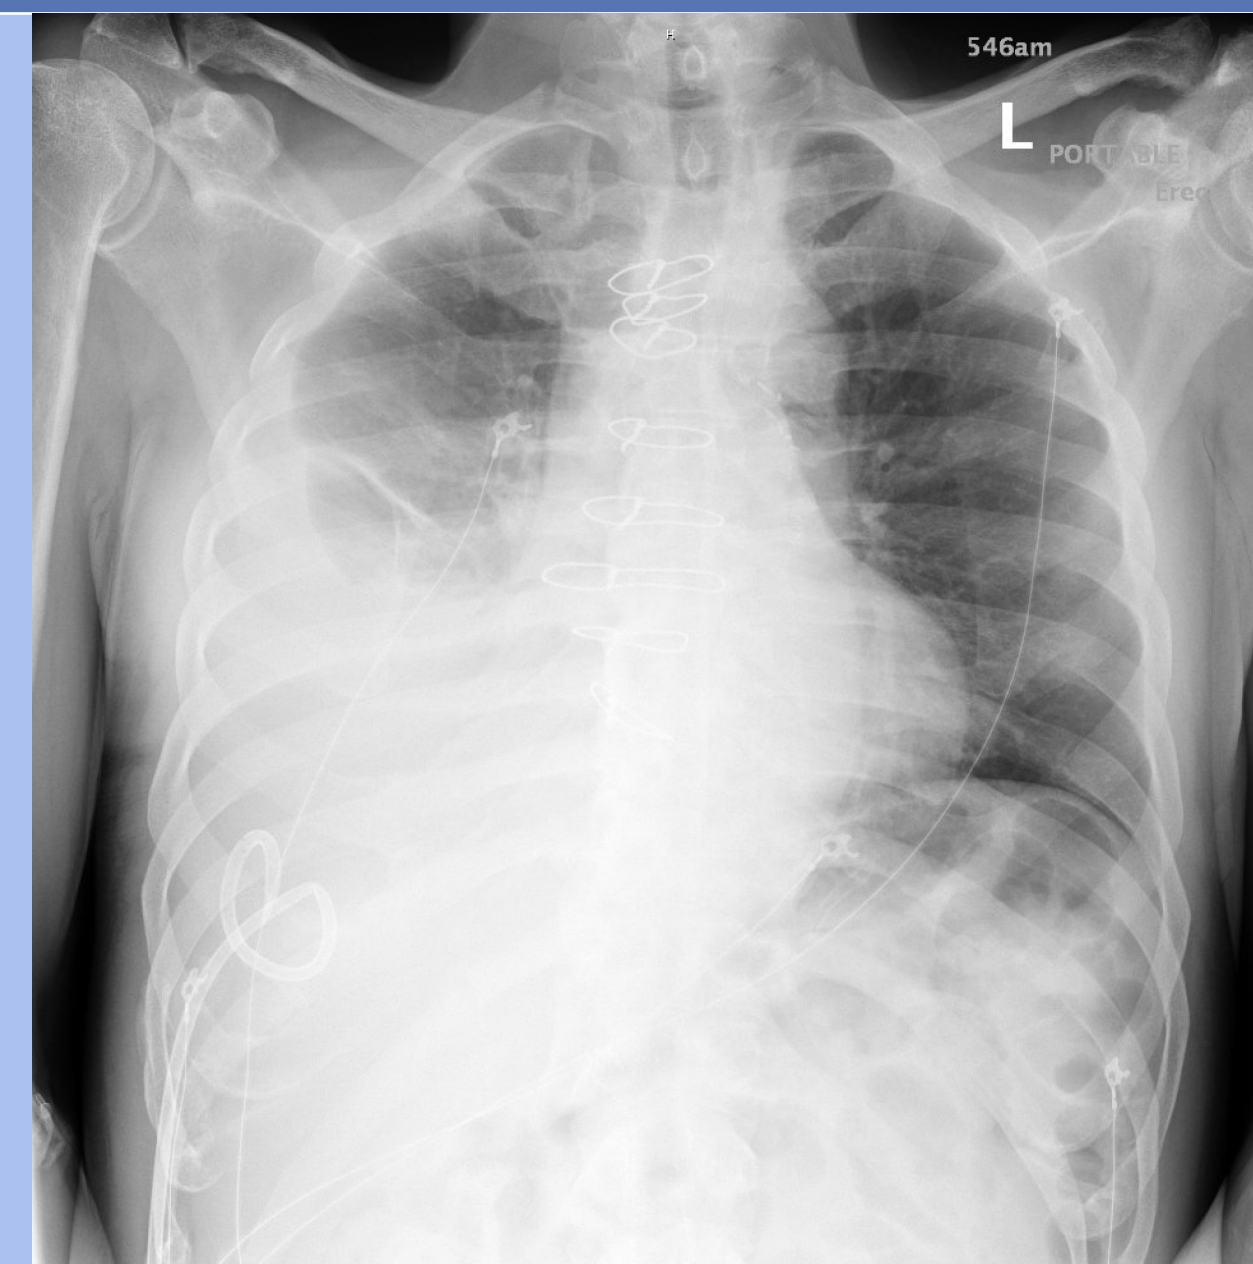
Initial chest X-Ray demonstrating large right pleural effusion
